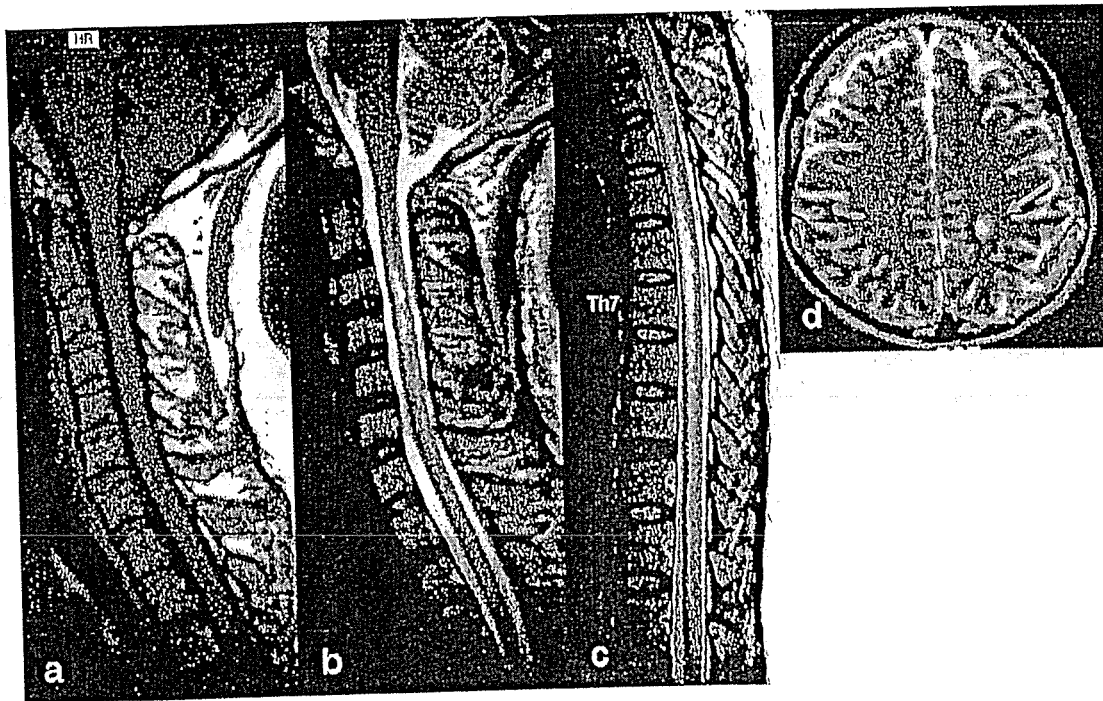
MRI before treatment (patient 1). (a) Sagittal T1-weighted image (T1WI) demonstrating swelling of the cervical spinal cord. (b, c) Sagittal T2-weighted image (T2WI) showing high signal intensity in the entire spinal cord. (d) Brain MRI demonstrating a high signal intensity area in the left parietal white matter.
